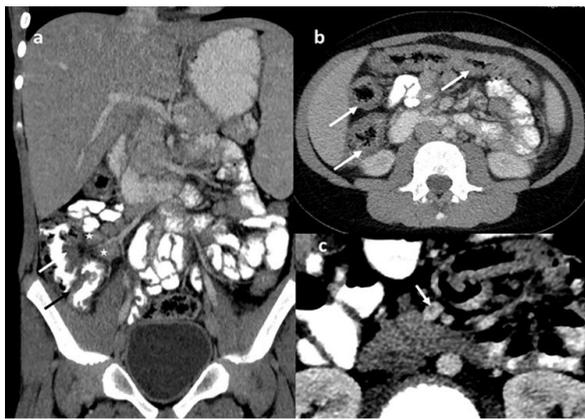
Multisystem inflammatory syndrome in children (MIS-C) in a 9-year-old boy presented with abdominal pain, nausea, vomiting, and fever 3 weeks after being infected with SARS-CoV-2 virus. Coronal (a) and axial (b) contrast-enhanced CT images show hepatosplenomegaly, mesenteric lymphadenopathies (white stars in a), and wall thickening of terminal ileum (black arrow), cecum, ascending and transverse colon (black arrows). 4 days after admission, the patient experienced abdominal pain again. Axial CT image (c) demonstrates partial thrombosis (white arrow in c) within the superior mesenteric vein (SMV).
